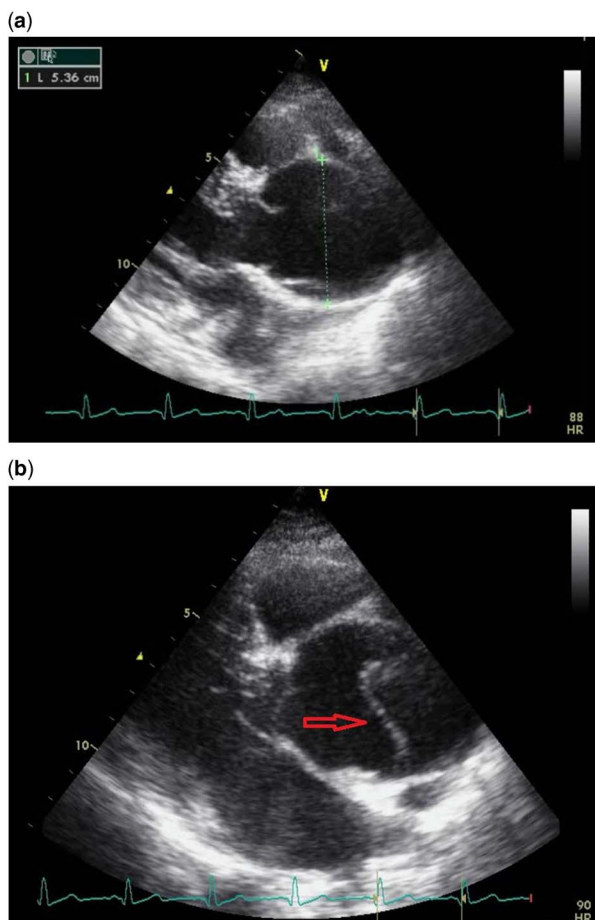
Transthoracic echocardiography and parasternal long-axis views: (a) dilated ascending aorta and (b) dissecting flap in the ascending aorta.
